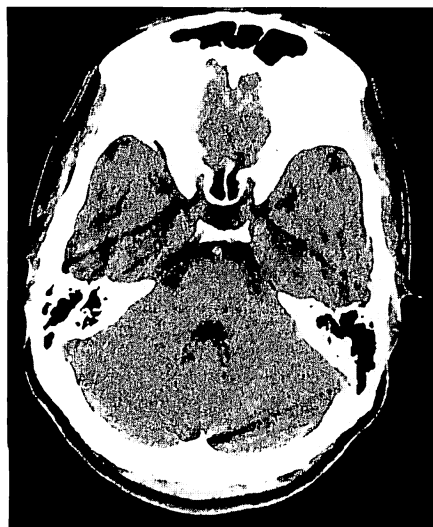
Computed tomography at admission, which was interpreted as normal. One hour had elapsed from ictus until this examination.
